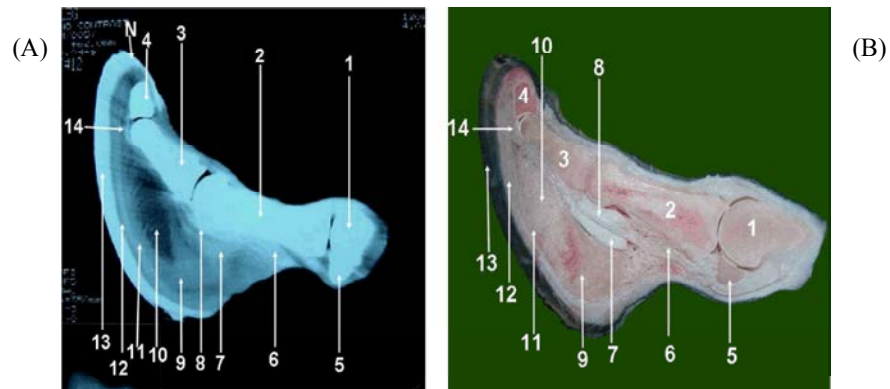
(A) Sagittal CT image and (B) cross section at the level of the middle of the nail. 1, distal extremity of the metacarpal bone ;2, proximal phalanx; 3, middle phalanx ;4, distal phalanx; 5, proximal sesamoid bone; 6, deep digital flexure tendon; 7, fibrocartilagenous enlargement of the deep digital flexure tendon; 8, middle scutum; 9,yellow bed; 10, digital cushion; 11, common capsule of the digital cushions; 12 epidermal layer of the sole; 13 sole pad; 14, distal scutum;;N, nail.
